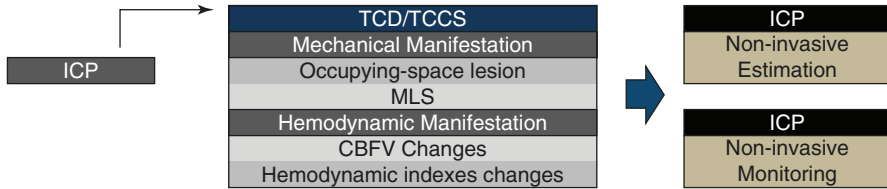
TCD/TCCS approach: Non-invasive estimation and monitoring of the ICP through sonographic mechanical and hemodynamic manifestations. *MLS*: Midline shift, *CBFV* Cerebral blood flow velocity, *ICP* Intracranial pressure
